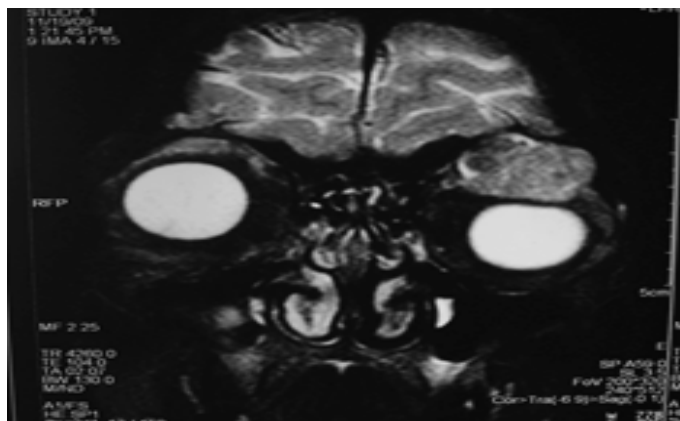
MRI, T2 Coronal image showing inferior displacement of the orbit
